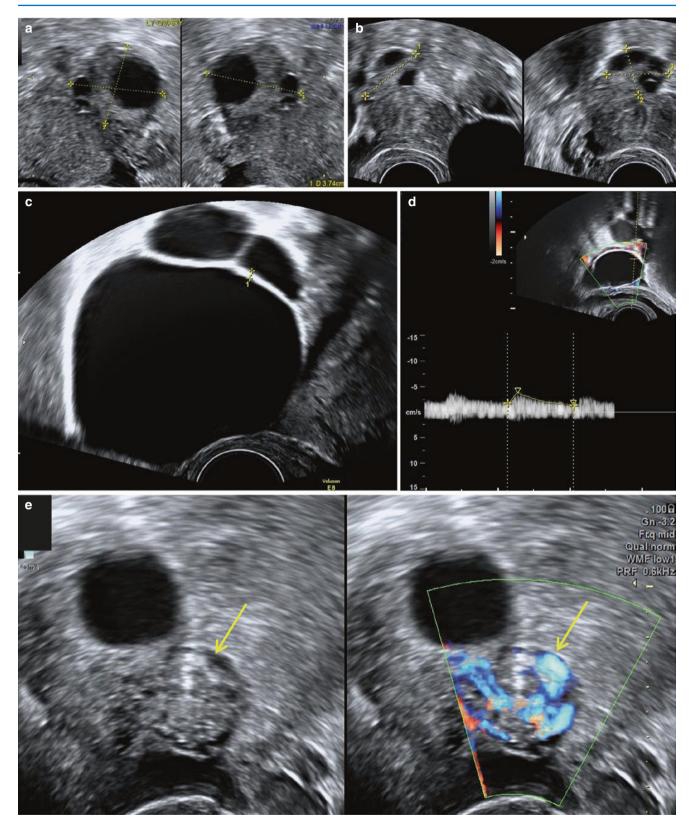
Benign paraovarian cyst with early torsion. (a, b) Normal right and left ovary. (c) Septate PO cyst seen. (d) Cyst walls showing flow. (e) Twisted pedicle showing whirlpool sign on greyscale and Doppler (*arrows*)
